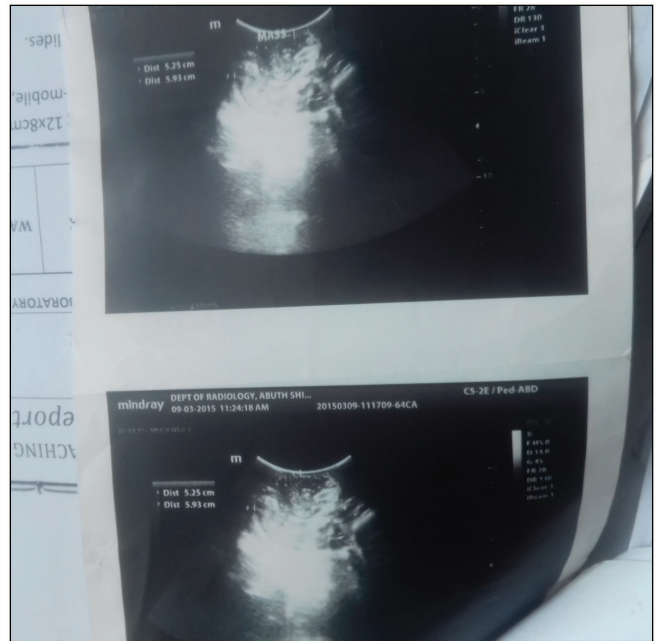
Ultrasonographic image
